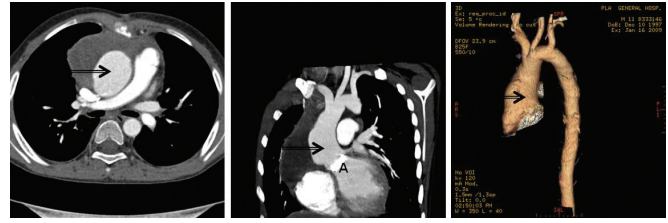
Postoperative computed tomographic scan of the patient. Arrows show the repaired ascending aorta, which has an almost normal anatomic form. The replaced aortic valvular prosthesis is indicated (A).
